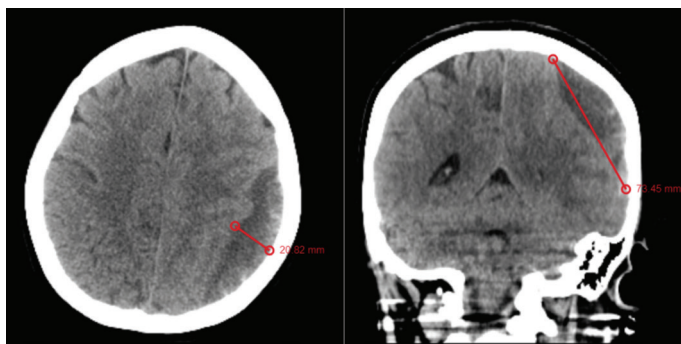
Imaging with a CT scan of the patient
